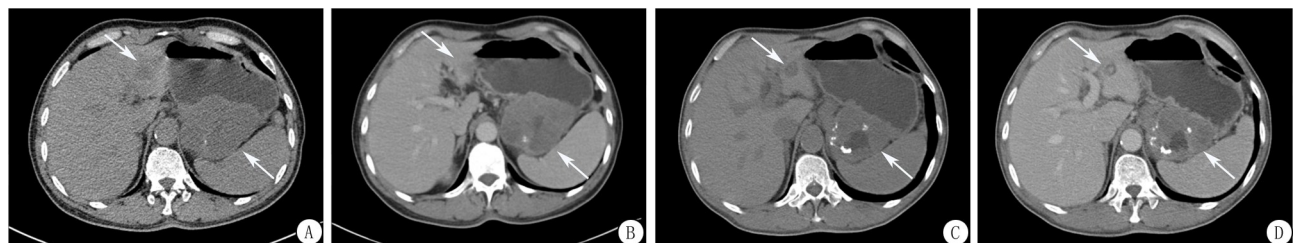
男, 61 岁, 胃间质瘤伴肝转移(箭头所示为两处靶病灶)。治疗后靶病灶大小变化不明显, 内部出现坏死及新增钙化, 平扫、静脉期靶病灶长径之和变化率分别为 8.8%、6.4%, 平扫平均 CT 值降低 1.6%, 静脉期平均 CT 值增加约 21.9%。参照
